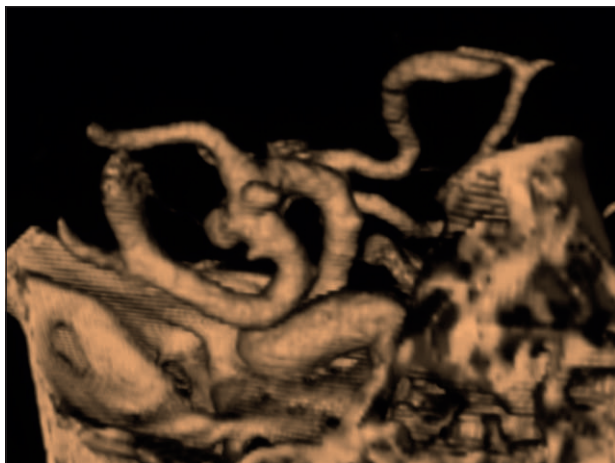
MCA aneurysms on feeder (CTA).
